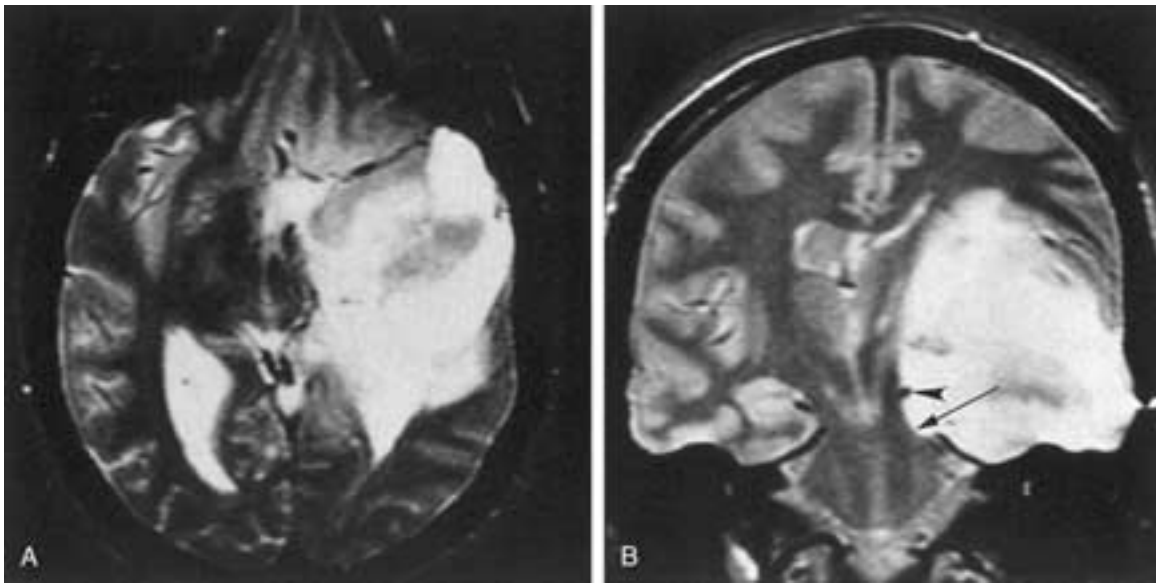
A 43-year-old male with malignant degeneration of a low-grade astrocytoma of the temporal lobe. A, Axial T2-weighted image shows a hyperintense mass involving the left temporal lobe. Edema and tumor are not separable. B, Coronal proton density image shows the mass involving the temporal lobe on the left to have high signal intensity. The mass extends superiorly and medially. The tumor mass herniates (*arrow*) over the free edge of the tentorium and displaces medially the basilar vein of Rosenthal (*arrowhead*) against the mesencephalon. The optic tract is compressed.
